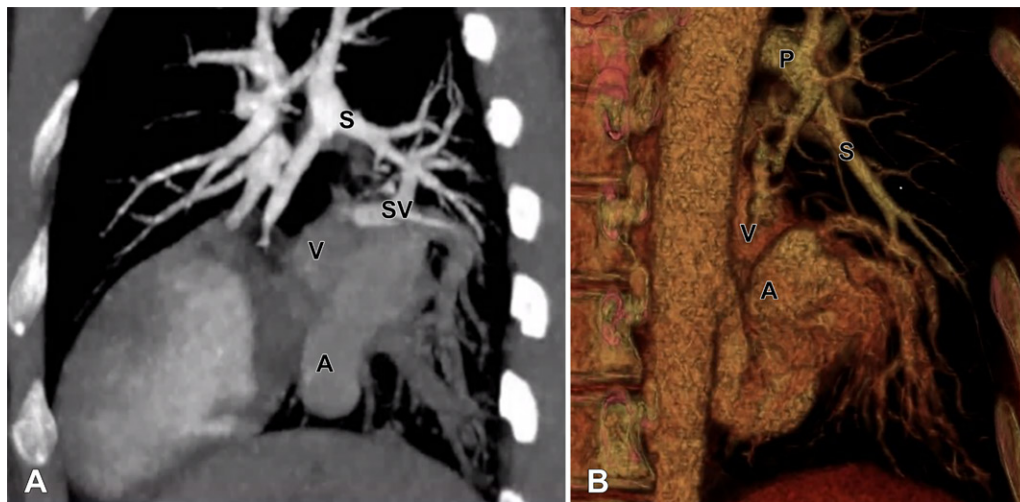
(A) Sagittal oblique multiplanar reformatted maximum intensity projection image from multiphase dynamic perfusion contrast-enhanced chest CT angiography during pulmonary arterial phase demonstrates the enhancing left upper lobe and superior segment of the left lower lobe arteries being supplied by a branch of the left pulmonary artery. There is slightly later enhancement of the basal segments of the left lower lobe being supplied by a large tortuous anomalous artery (A) from the descending aorta. The left lower lobe arteries drain into the enlarged left inferior pulmonary vein (V). A vein draining the superior segment of the left lower lobe (SV) demonstrates earlier enhancement than the remaining left lower lobe veins. There is absence of the left lower lobe basilar artery distal to the origin of the superior segmental branch (S) from the left pulmonary artery (P in B). (B) Volume-rendered image centered at the left lower lobe demonstrates the anomalous artery (A) arising from the descending aorta.
